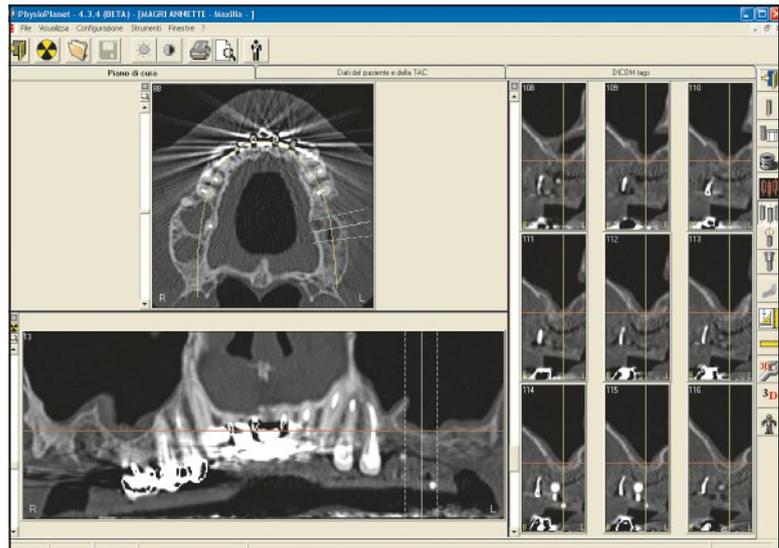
Case 2: Single implants. Cone beam computed tomography.
